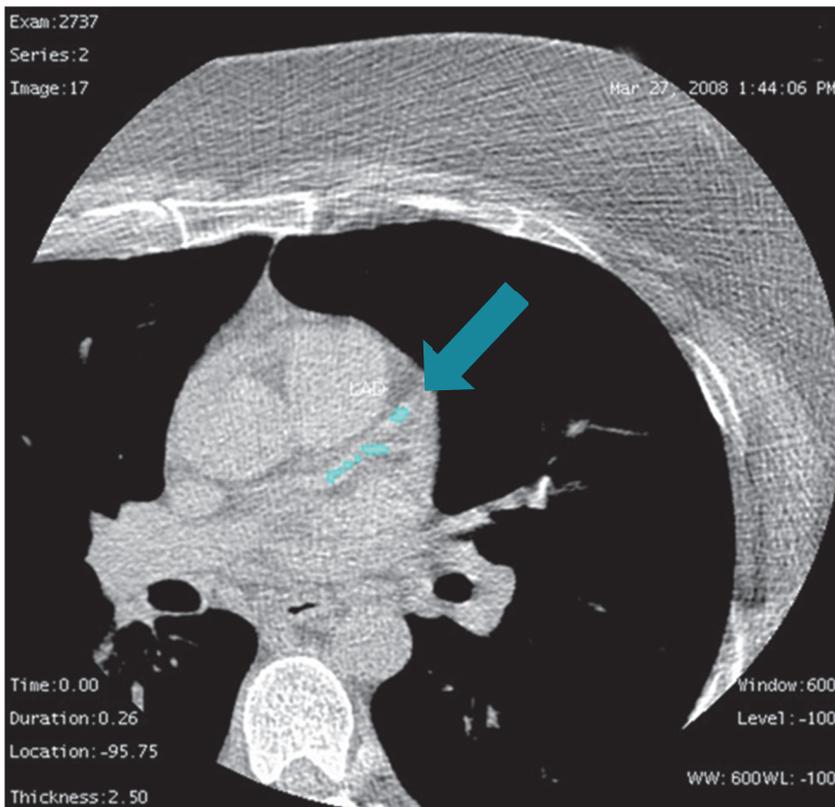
A Cardiac computed tomography scan for calcium scoring showing coronary artery calcification of the left anterior descending artery.
